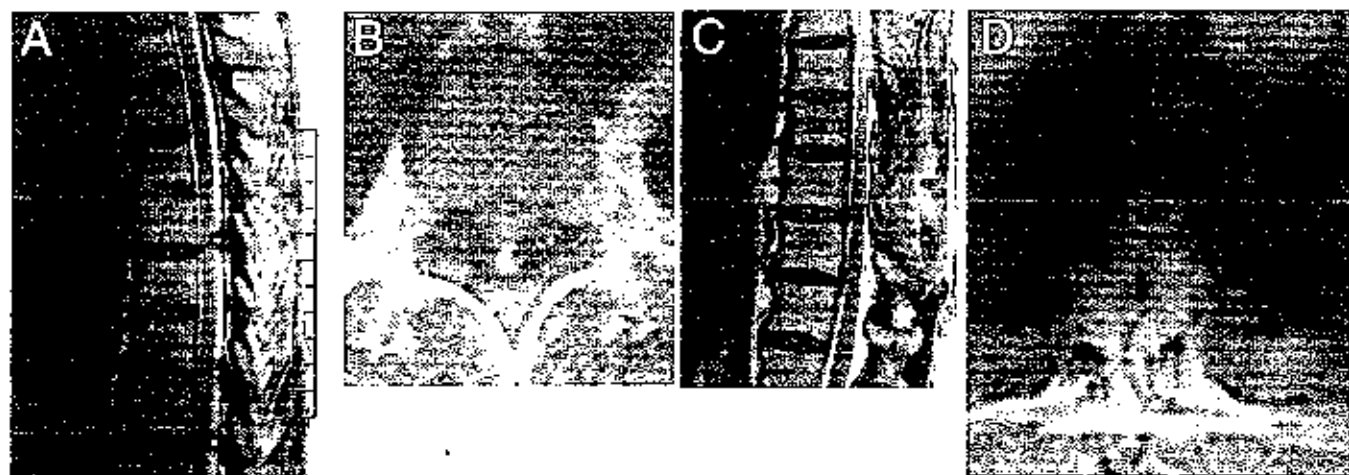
Case 2. Preoperative sagittal (A) and axial (B) T2-weighted MR images depicting spinal cord hyperintensity (increased signal) at the level of T-7, T-9, and T-10 due to spinal cord compression. Bilateral and multilevel calcified synovial cysts (*asterisks*) are evident. Postoperative sagittal (C) and axial (D) T2-weighted MR images demonstrating resection of cysts.
